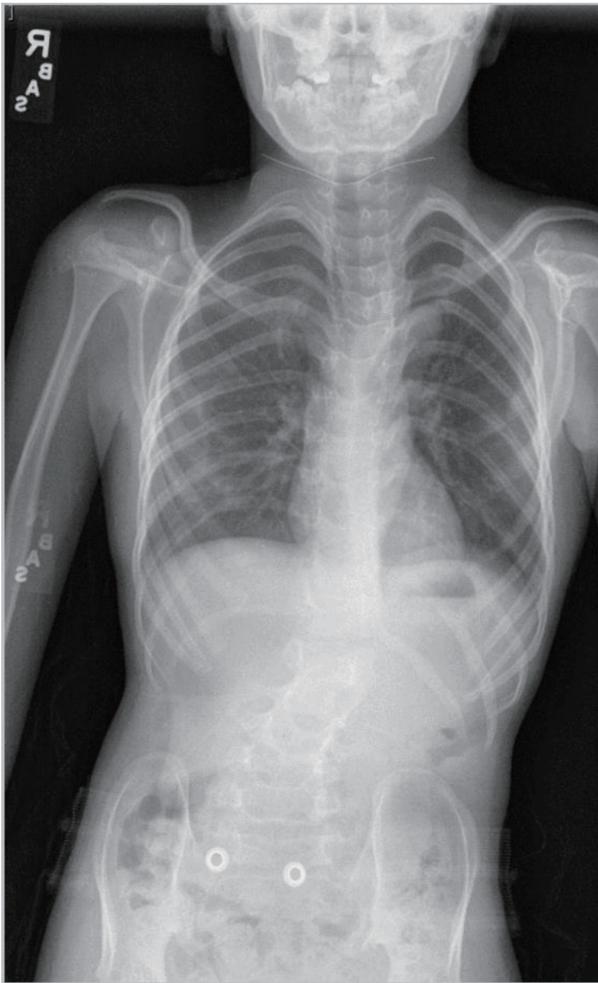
Preoperative vertebral radiograph showing scoliosis.
